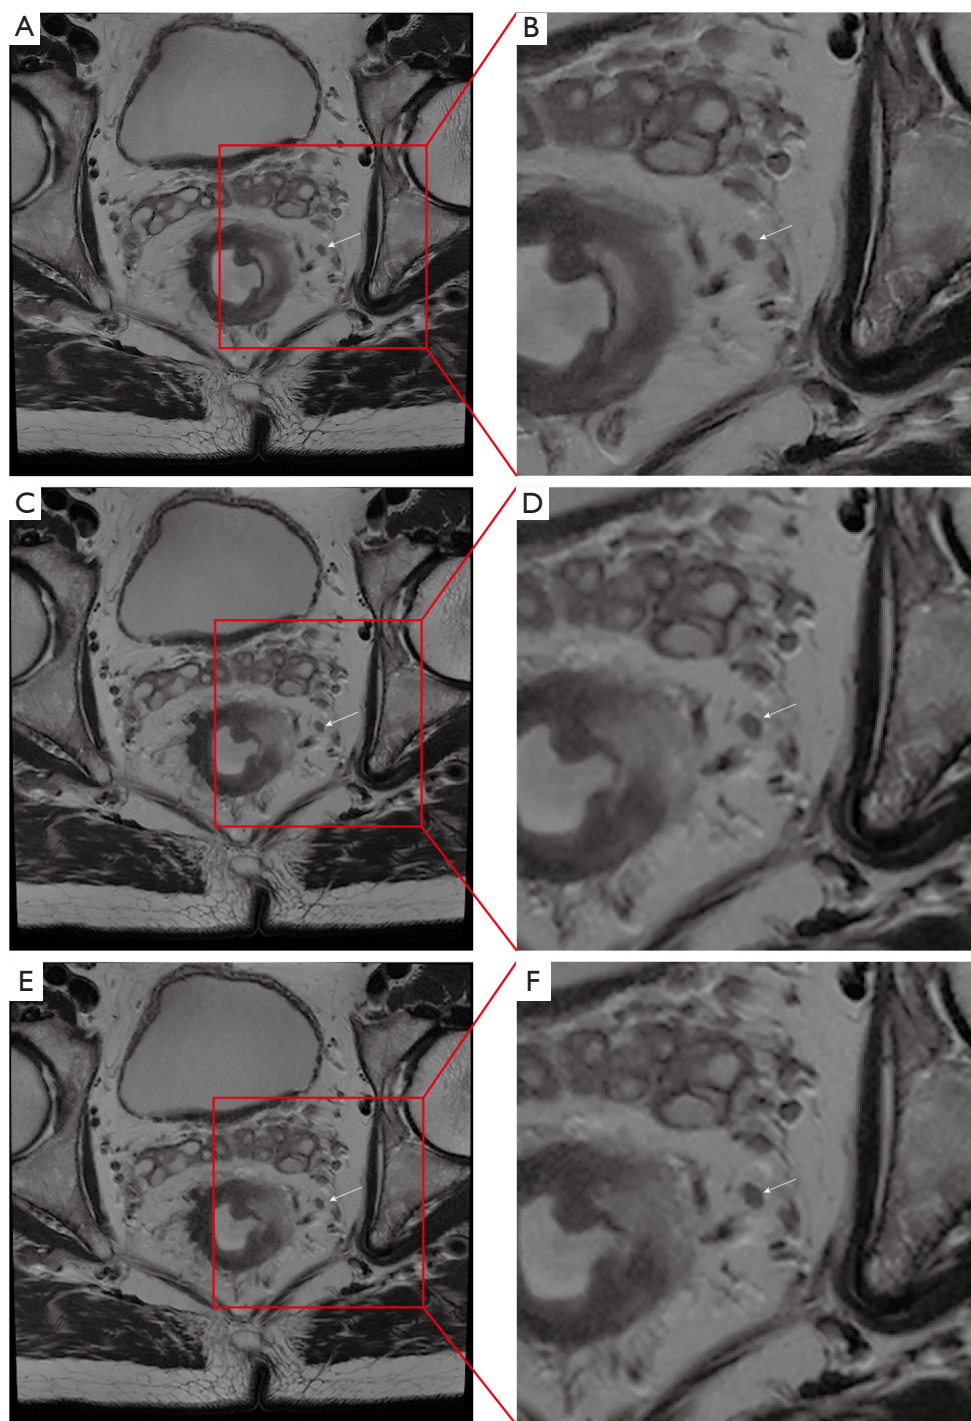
MRI of another 68-year-old male patient with pathologically diagnosed T3 rectal cancer. (A,B) The picture of ACS-T2WI; (C,D) the picture of CS-T2WI; (E,F) the picture of PI-T2WI. Where (A,C,E) are the original images and (B,D,F) are the magnified images, the magnification is 2. White arrows point to lymph node, the selected part in the red box is the enlarged part. On the ACS-T2WI images, the margins of lymph nodes were irregular, suggesting a higher suspicion of lymph node metastasis of rectal cancer. However, on the CS-T2WI and PI-T2WI images, the blurred margins made it difficult to assess lymph node metastasis. MRI, magnetic resonance imaging; T2WI, T2-weighted imaging; ACS, artificial intelligence assisted compressed sensing; CS, compressed sensing; PI, parallel imaging.
